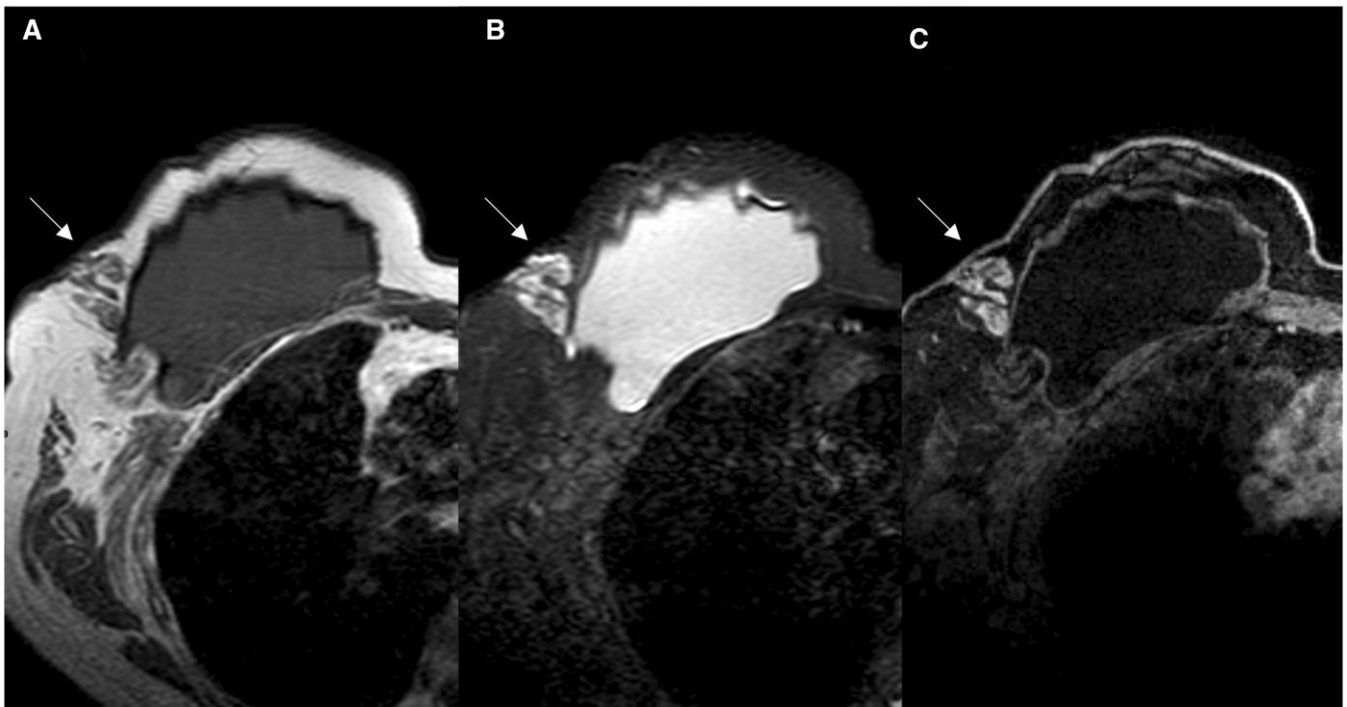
Local recurrence in breast implant reconstruction with acellular dermal matrix (ADM) at MRI. Sixty-four-year-old women who underwent nipple-sparing mastectomy using human ADM; MR images show the tumour recurrence in the upper-outer quadrant in the periprosthetic site, along the implant, resulting hypointense in T1-sequence (A), hyperintense in STIR (B), and with inhomogeneous contrast enhancement (C) on DCE-sequences.
